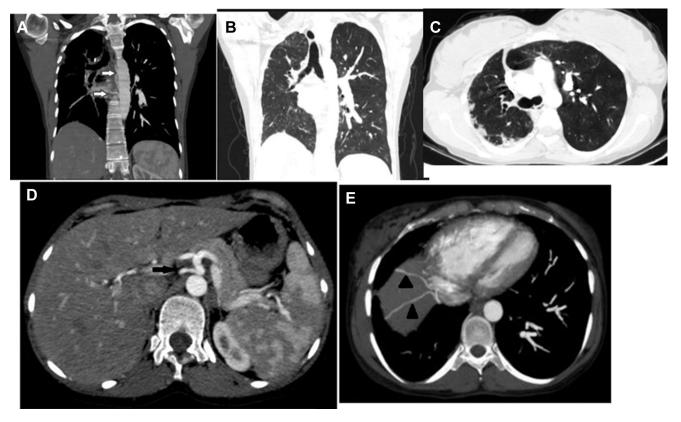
(A, B) Coronal CT angiography maximum intensity projection (MIP) images demonstrate right mediastinal and cardiac shifts, contralateral lung hyperinflation, diminished vascularity, systemic collaterals arising from aorta [arrow on (A)]. (C) Axial CT angiography on parenchymal window shows herniation across the midline and subsegmenter parenchymal infarctions in the right upper lobe. (D) Axial CT angiography images demonstrate collaterals arising from celiac trunkus (black arrow) and (E) systemic perfusion via subdiaphragmatic collaterals (arrowheads).
